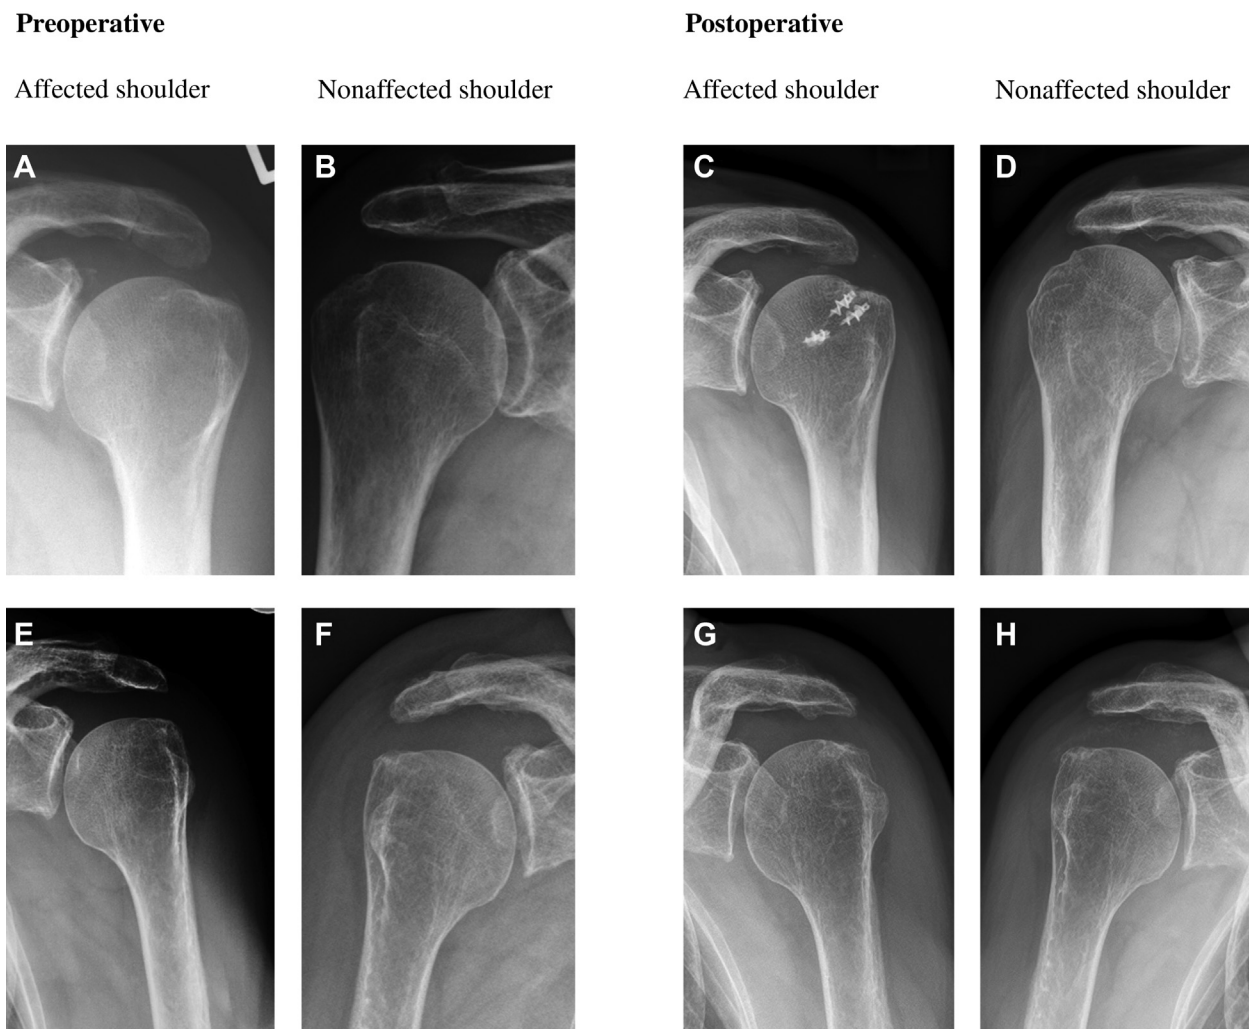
Pre- and postoperative (8-year follow-up) radiographs of both the affected shoulder and the contralateral side. Top row: (A, B) A 77-year-old male patient who underwent arthroscopic rotator cuff repair (ARCR) for an anterosuperior tear of the left shoulder in 2011. After 6 months, an arthroscopic débridement with tenotomy of the long head of the biceps tendon was performed on his right shoulder because of an irreparable massive rotator cuff tear. (C, D) At final follow-up, radiographs show a mild progression of secondary glenohumeral osteoarthritis at the left shoulder, whereas superior migration of the humeral head was observed at the right side, indicating a cuff tear arthropathy. The Simple Shoulder Value was 90% for the left shoulder and 50% for the right side. Bottom row: (E, F) An 81-year-old female patient who underwent ARCR for a tear of the supraspinatus tendon in the left shoulder in 2010. No surgery was performed on the contralateral side. (G, H) No progression in glenohumeral osteoarthritis was seen in both shoulders, and the SSV was reported as 90% for both sides.
